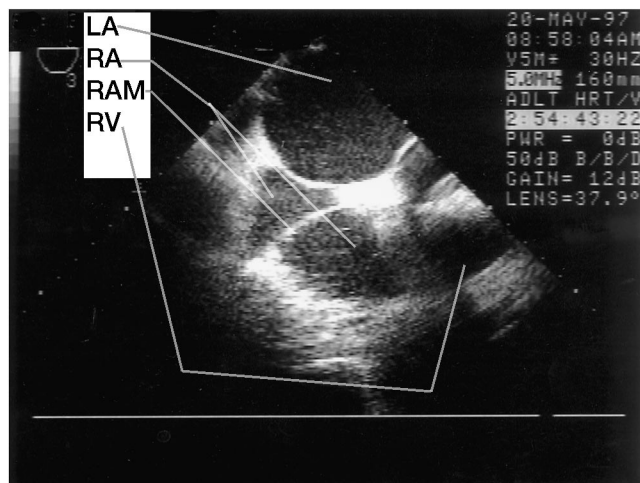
Transesophageal echocardiographic view of the left atrium (LA), right atrium (RA), right atrial membrane (RAM), and right ventricle (RV) in partial view.
